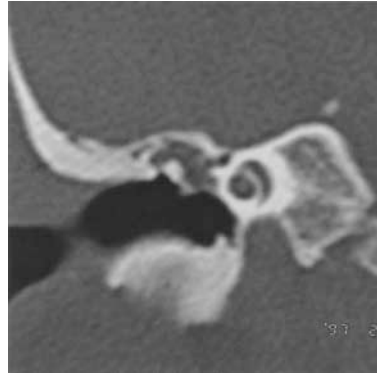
CT of epitympanic cholesteatoma. Note the density in the epitympanum around the head of the malleus and erosive blunting of the corner of the upper bony canal wall (scutum).
